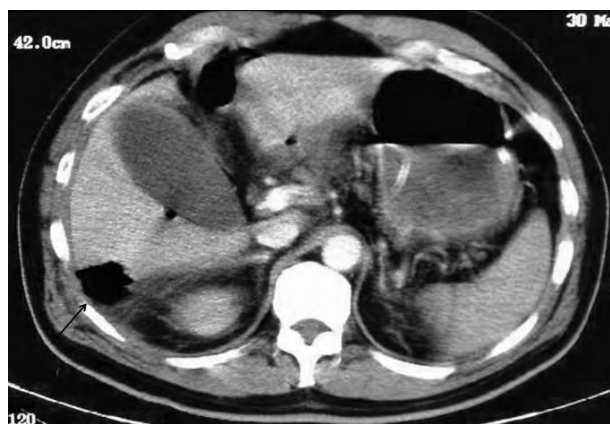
Abdominal computed tomography scan – gas filled abscess in the right lobe of the liver.
